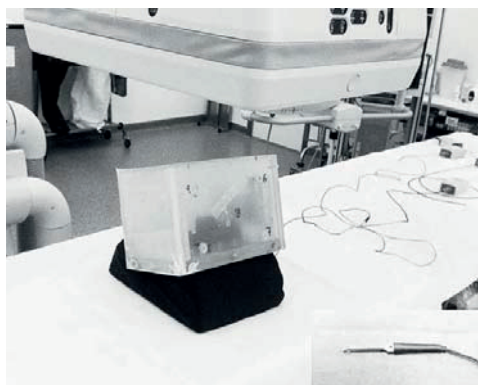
♦ (A) The 7 metallic spheres in the reference plate, together with two 5-DOF electromagnetic sensors, enabled the registration of a CT image space in the magnetic field. (B) The 7 metal spheres that were cast in the reference plate were displayed as green dots in the magnetic field. A CT image space was manually registered in the magnetic field by moving the CT image until the metal spheres in the image covered the corresponding green spheres in the magnetic field.
